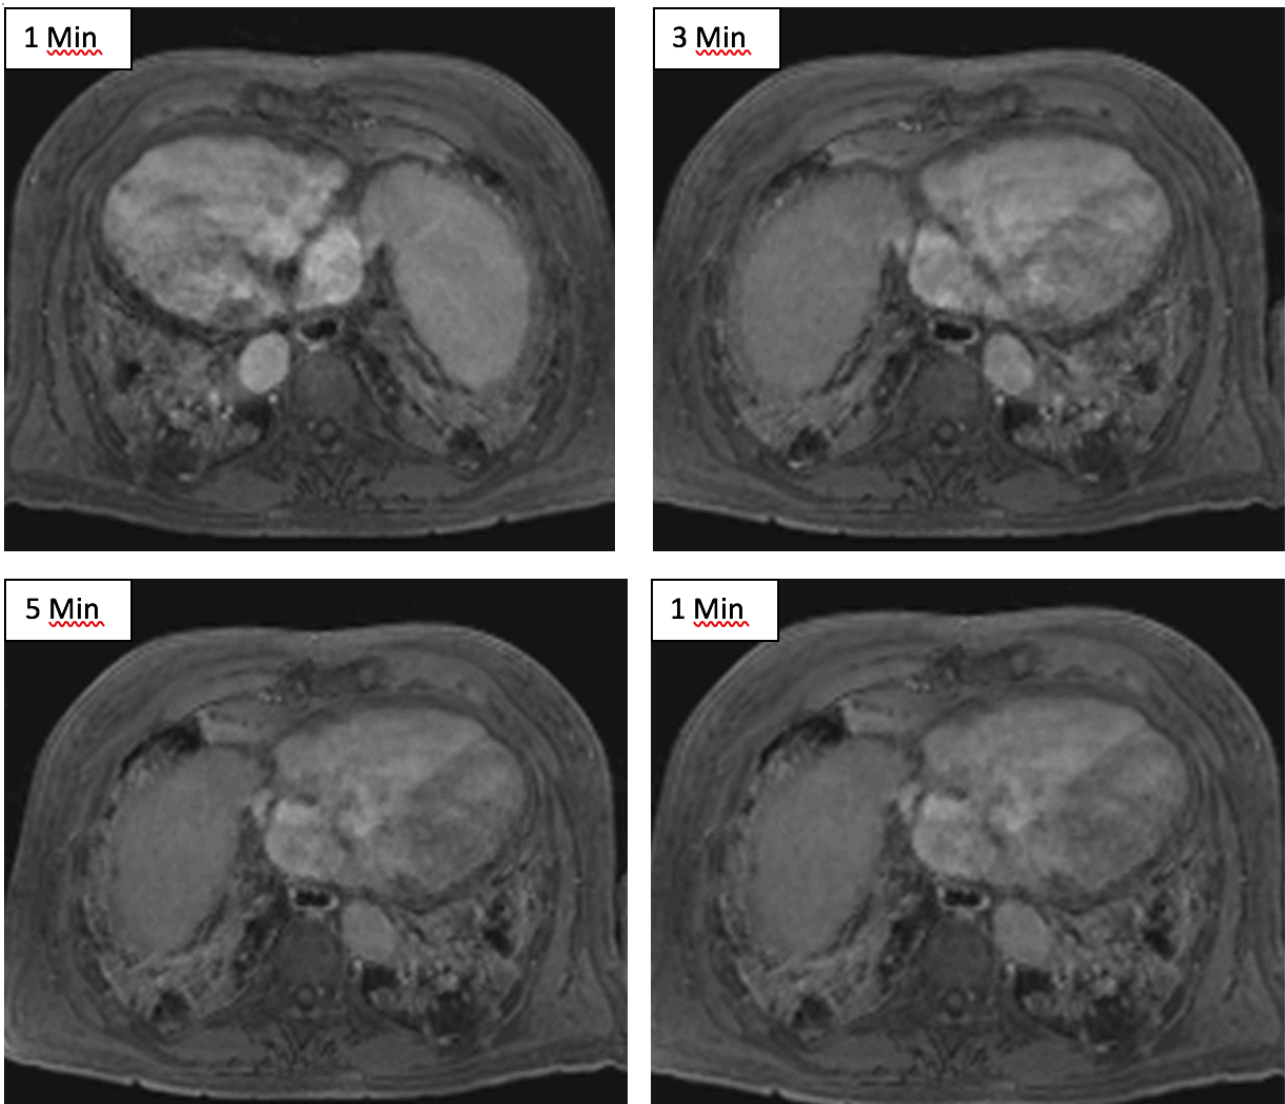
SSc-ILD, DCE-MRI, VIBE contrast enhancement evaluation (1, 3, 5 and 10 minutes after contrast administration): delayed enhancement.
